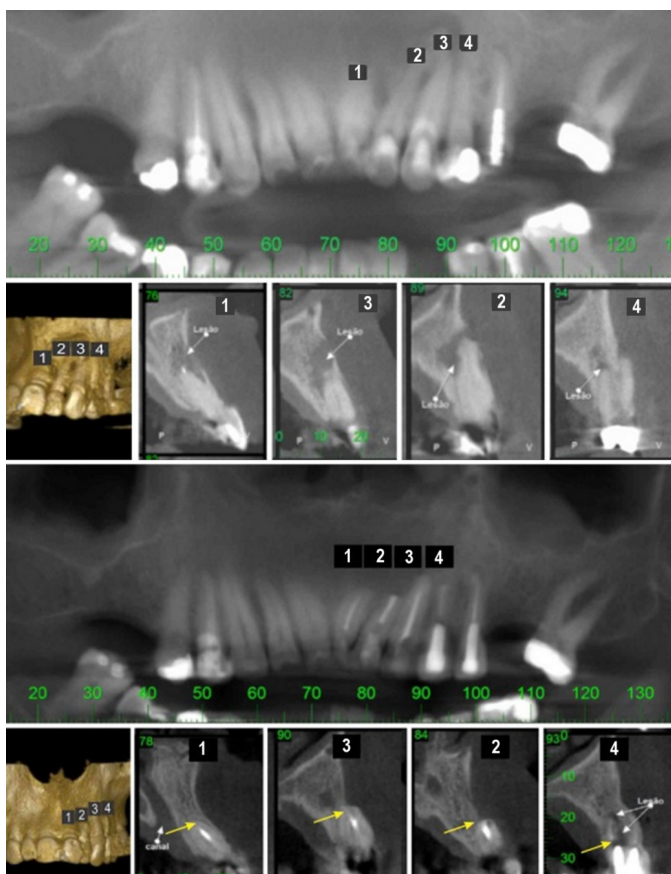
Preoperative (top) and 6-month postoperative (bottom) cone-beam CT images showing affected teeth treated with either MTA (teeth 1 and 3) or PBS (teeth 2 and 4) as root-end filling materials.
